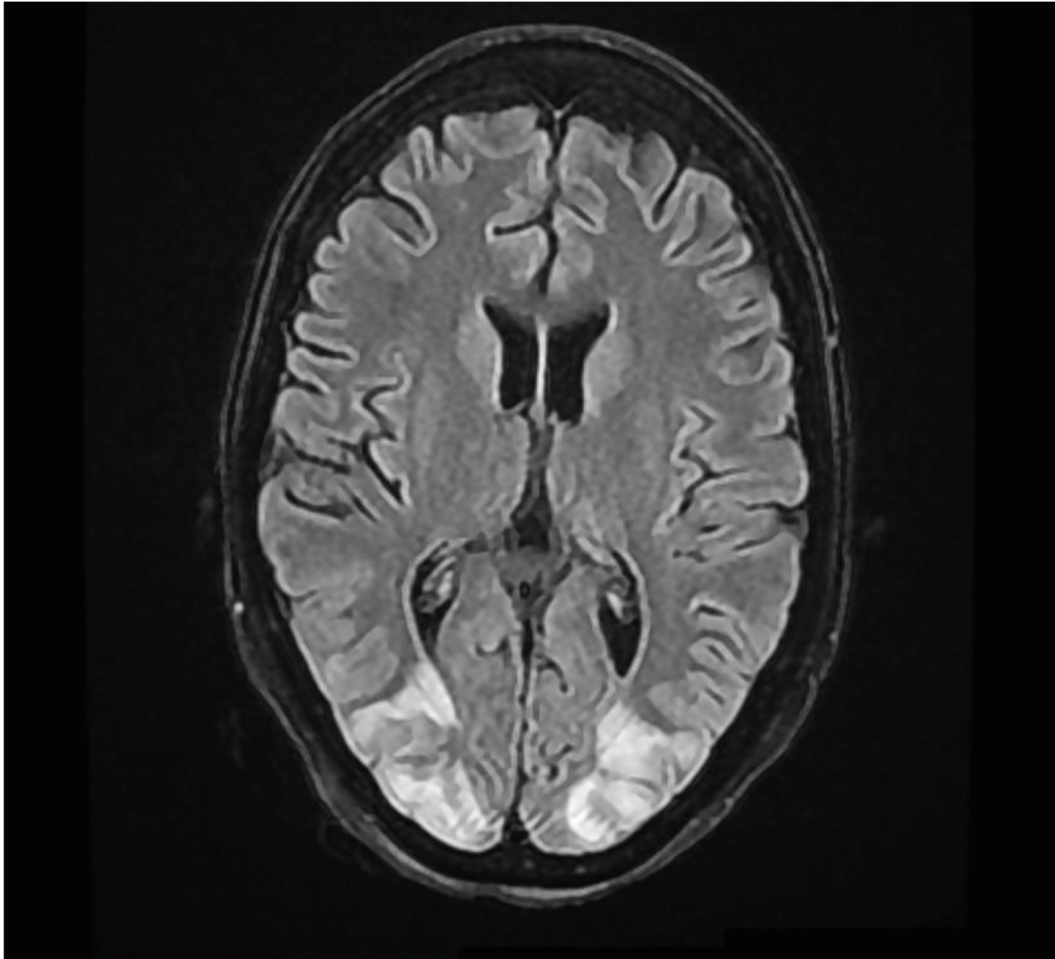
MRI flair image showing signal change in bilateral parieto-occipital region.
